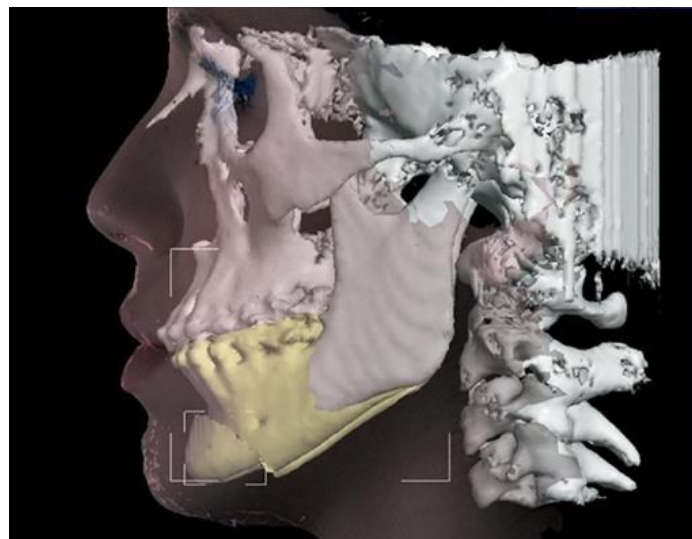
Prediction planning on the CBCT scan for correction of Class III skeletal discrepancy with surgical correction of the mandible by genioplasty and mandibular sagittal osteotomy. [Adapted from (10)]
